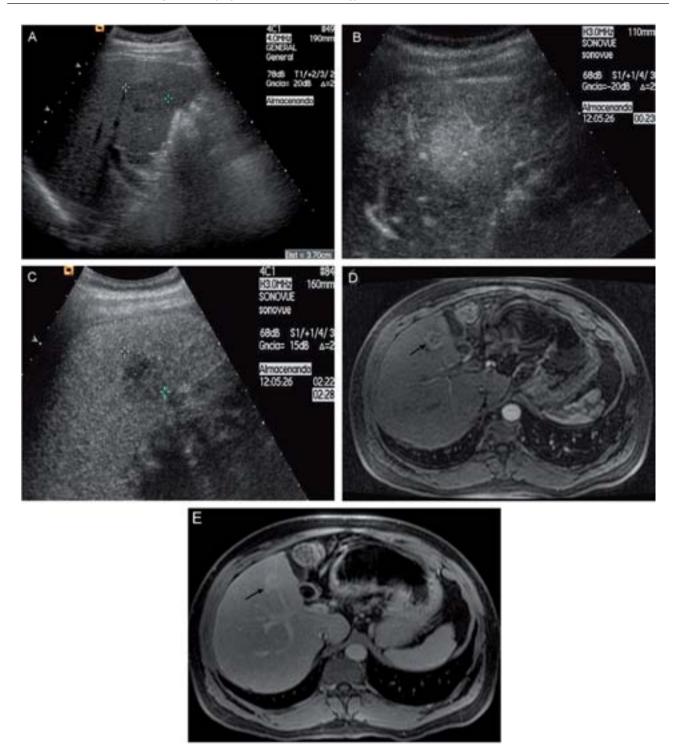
A patient with cirrhosis secondary to HCV infection with a hepatic lesion that was diagnosed as an intrahepatic cholangiocarcinoma by a percutaneous biopsy. In this case, the vascular pattern on CEUS was indistinguishable from HCC. A) In the baseline ultrasound, a 37 mm, hypoechoic nodules was identified in the right liver lobe (cursors). B) In the arterial phase of CEUS, the nodule displayed a homogeneous contrast uptake. C) In the delayed phase the CEUS showed contrast washout. D) In the arterial phase of the MRI, an almost complete uptake of the lesion is observed. E) Persistence of the uptake is identified in the delayed venous phase of MRI.
